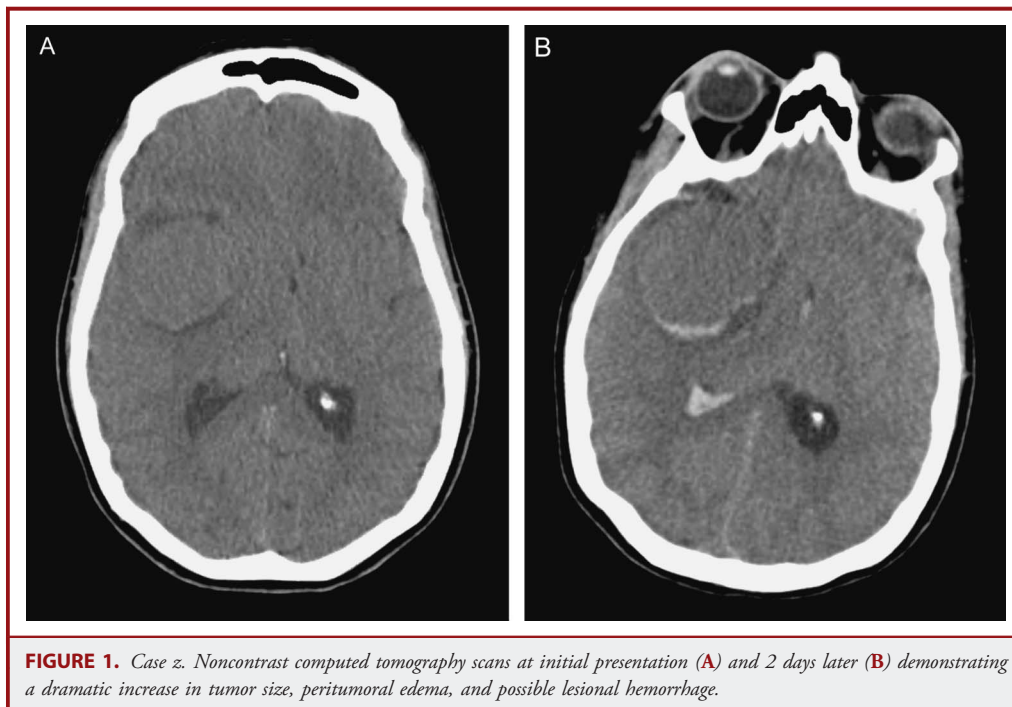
Case z. Noncontrast computed tomography scans at initial presentation (A) and 2 days later (B) demonstrating a dramatic increase in tumor size, peritumoral edema, and possible lesional hemorrhage.
